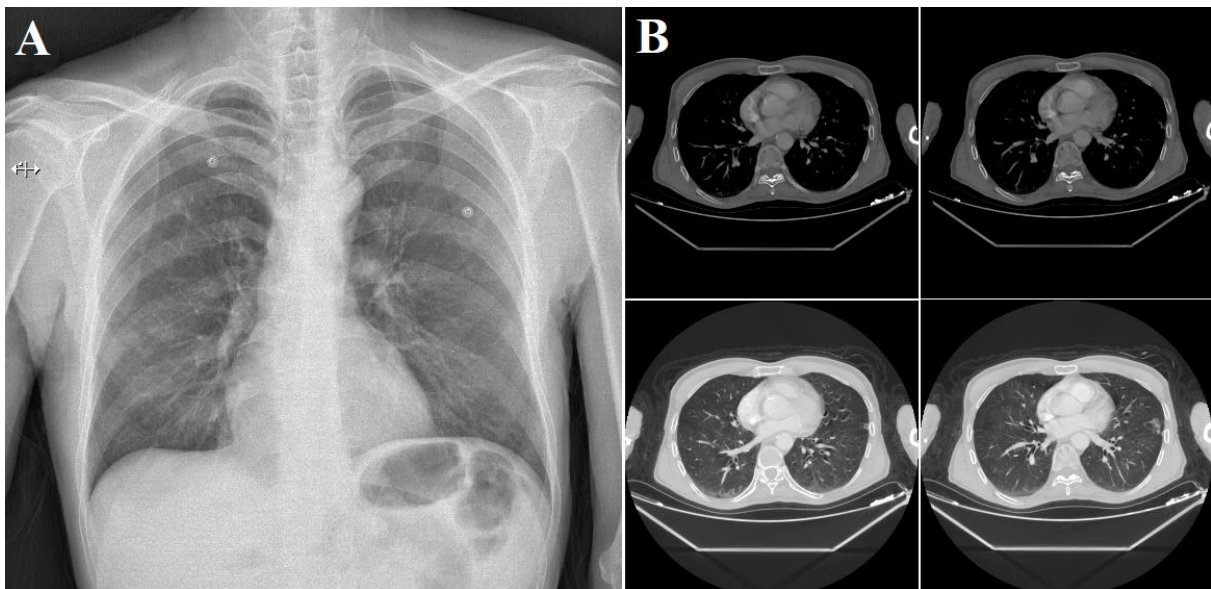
A. Preoperative Chest X-ray B. Images of preoperative CT
